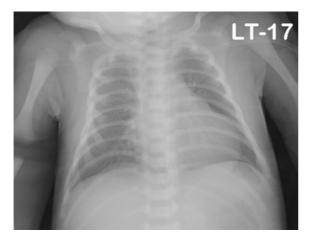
Chest x-ray showed normal.
